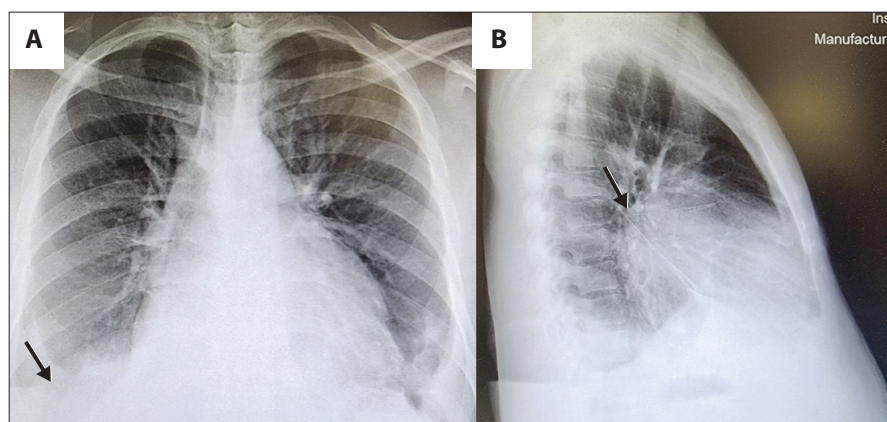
Anteroposterior (A) and lateral (B) chest radiographs preoperatively. On the left, note the blunted, right costophrenic angle and marked prominence of the perihilar vasculature. On the right, fluid in the right horizontal and oblique fissures is indicated by the black arrows.
